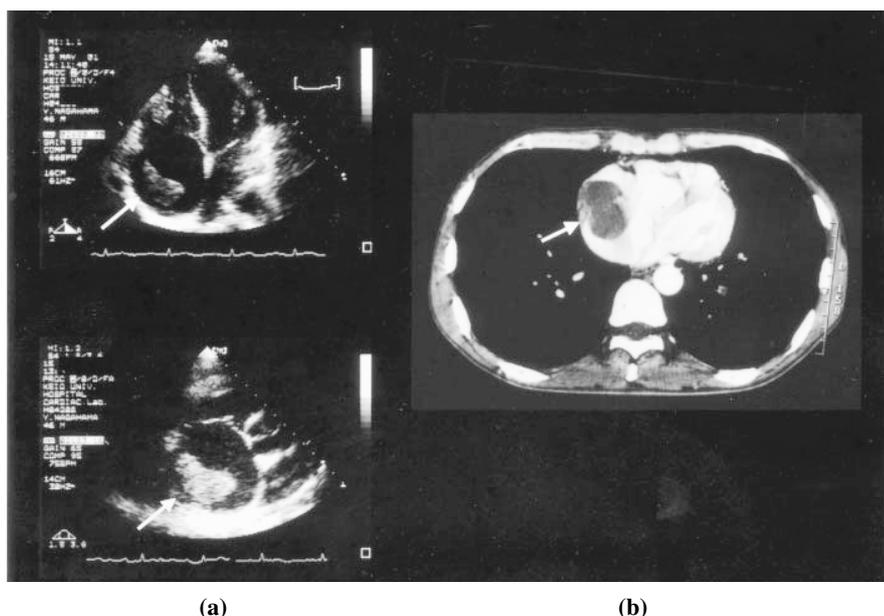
Echocardiography and chest CT before the operation. (a) Echocardiography and (b) chest CT revealed the presence of a homogeneous, well-defined and mobile mass (70 x 60 mm) on the lateral wall of the right atrium (→).
